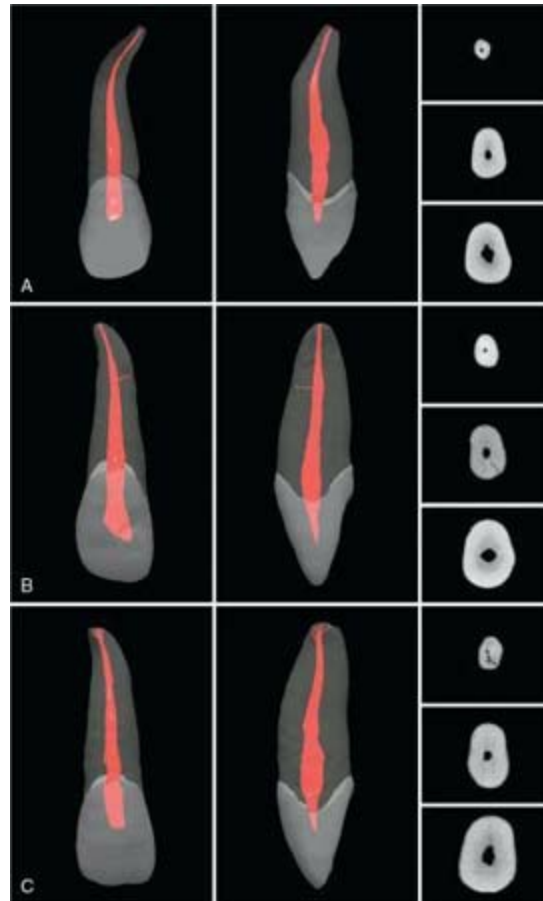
μ CT scans of maxillary lateral incisors. A, Common anatomic presentation. B, Lateral incisor with a large lateral canal, which is common. C, Lateral incisor with an apical delta. All teeth are shown from both a buccal (vestibular) and a proximal perspective, along with the cross-sectional anatomy at the coronal, middle, and apical levels. (See Video 7.4 online at the Expert Consult site for rotational views of these teeth.)
